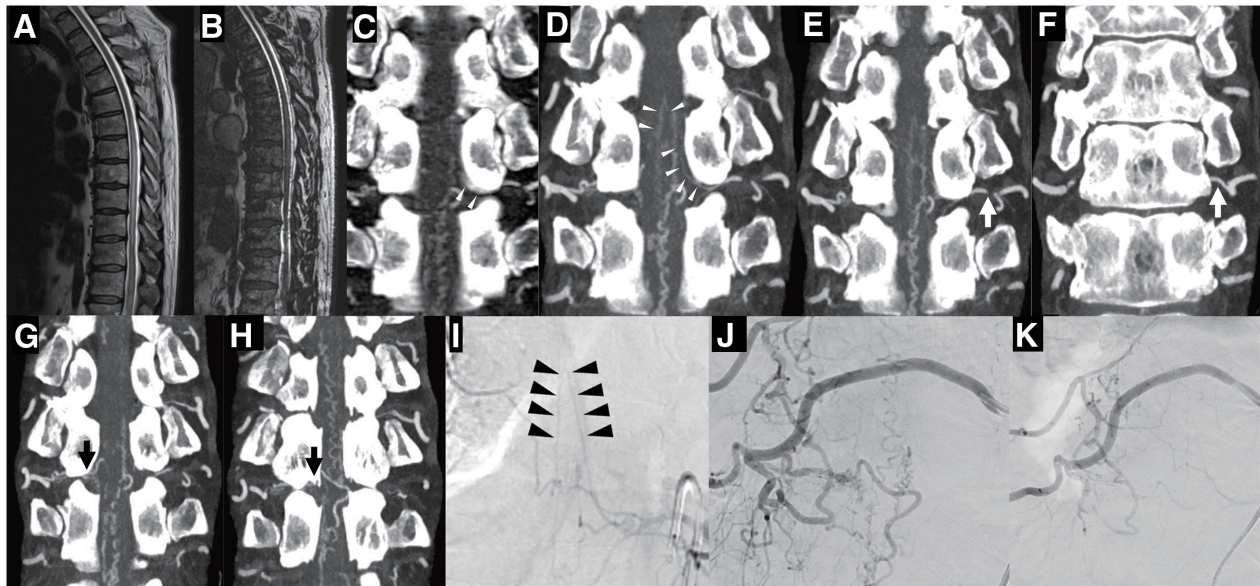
(A) A sagittal section of the MRI image demonstrates hyperintense signal lesions in the thoracic spinal cord below Th6 on a T2-weighted image. (B) A sagittal section of the CISS image displays the tortuous veins on the surface of the spinal cord. (C) CTA without sublingual NTG did not depict the AKA (white arrowhead). (D) CTA with sublingual NTG depicts the hairpin curve of the AKA excellently (white arrowhead). (E and F) The continuity from the left 10th intercostal artery to the ventral side of the spinal cord is observed on the coronal image of CTA (white arrow). (G and H) The coronal view of the CTA reveals a shunt supplied by the right 10th intercostal artery; however, the precise shunt point cannot be definitively determined (black arrow). (I) A preoperative spinal angiography reveals that the AKA originates from the left 10th intercostal artery, which is consistent with the CTA findings (black arrowhead). (J) A spinal angiography at the right 10th intercostal artery displays the SDAVF. (K) After embolization using NBCA, the shunt is successfully occluded. AKA, artery of Adamkiewicz; CISS, constructive interference in steady state; NBCA, N-butyl-2-cyanoacrylate; NTG, nitroglycerin; SDAVF, spinal dural arteriovenous fistula
